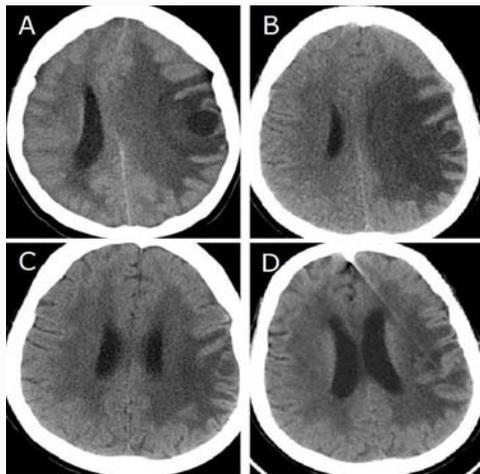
Head CT scans showed brain metastases initially gradually shrank and disappeared. (A) 17 January 2014; (B) 3 July 2014; (C) 15 January 2015; (D) 6 May 2016.
